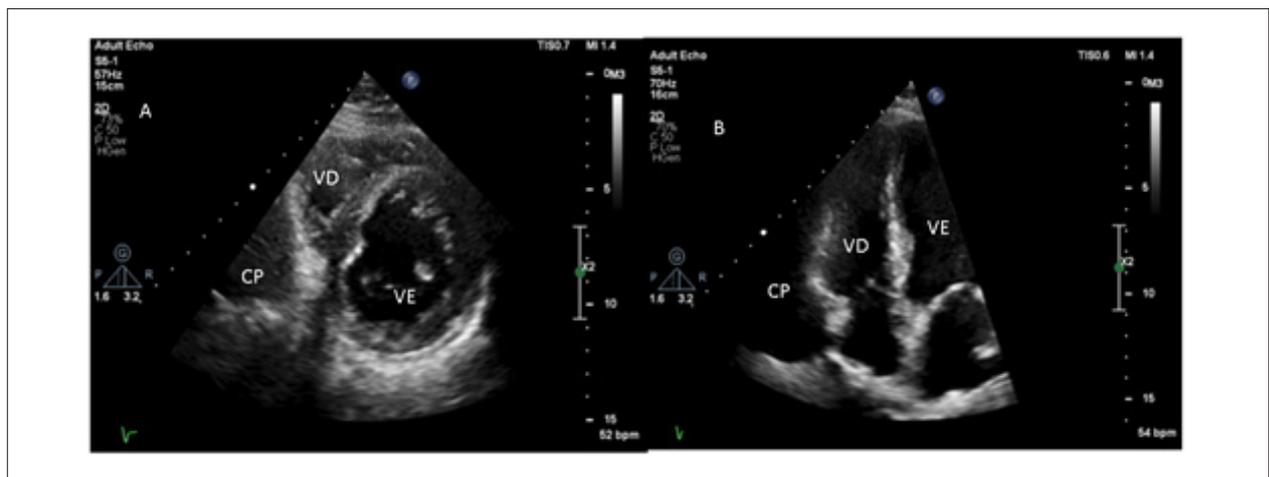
Short-axis (left image) and four-chamber (right image) Dopplerechocardiogram images showing the pericardial cyst (CP) as a luminescent area posterior to the right ventricle (VD). VE=Left ventricle.
